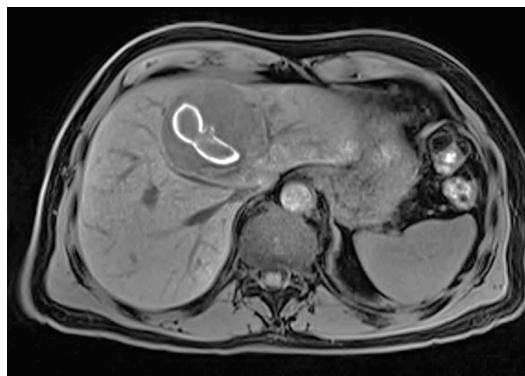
T1-weighted axial MRI at the level of right hepatic vein demonstrating mass with intratumoural haemorrhage.
